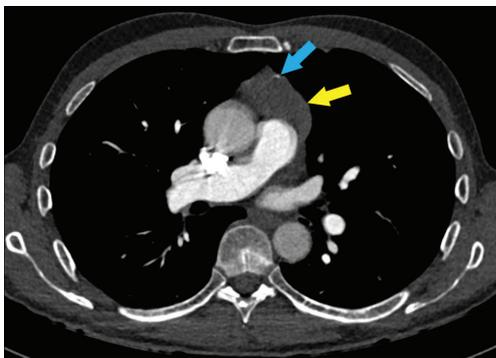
Case 2 imaging. Axial CT angiogram of the chest showed a prevascular mediastinal mass (yellow arrow) with small peripheral calcifications (blue arrow). CT, computed tomography.
